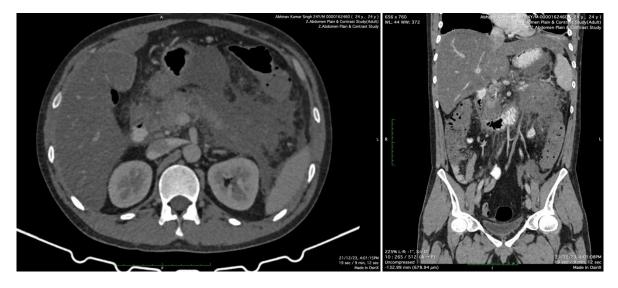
Axial and coronal CT image of Acute necrotising pancreatitis (Modified CTSI score 10/10)
